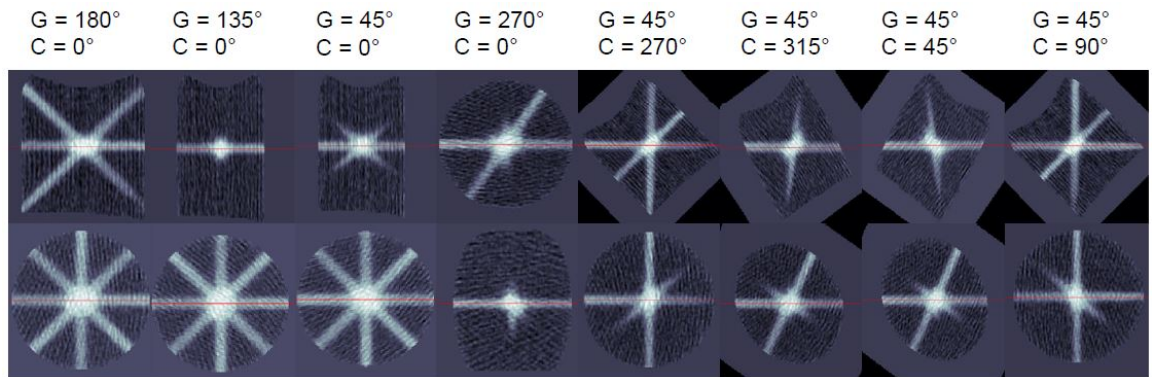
Orthogonal slices of the processed CBCT images of each beam using the 5 mm diameter MLC field. The gantry and couch angles are labeled above the corresponding orthogonal images.
